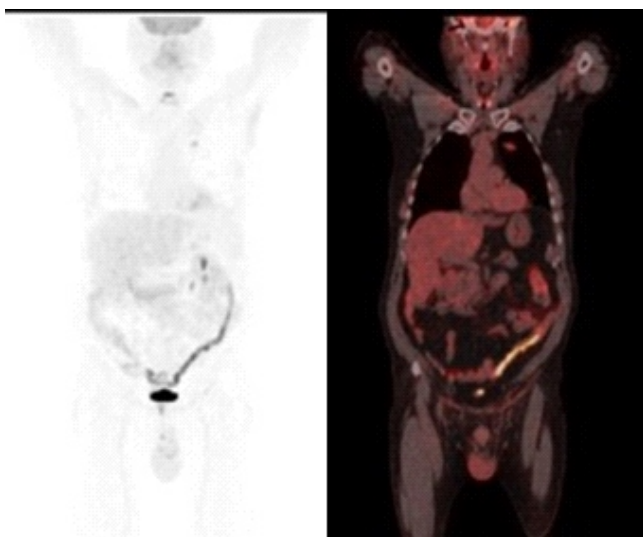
A 62 year old patient with lung cancer and type 2 diabetes treated with metformin. Fluorine-18-FDG PET/CT showed typical aspecific increased uptake in bowel due to diabetes.
